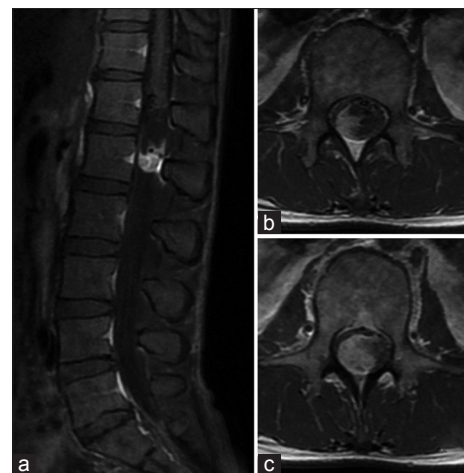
T1 image with gadolinium MR image, sagittal view (a) and axial views T12-L1 intervertebral disc level (b) and L1 vertebral body level (c). Homogeneously enhanced and lobulated tumor was clearly seen
